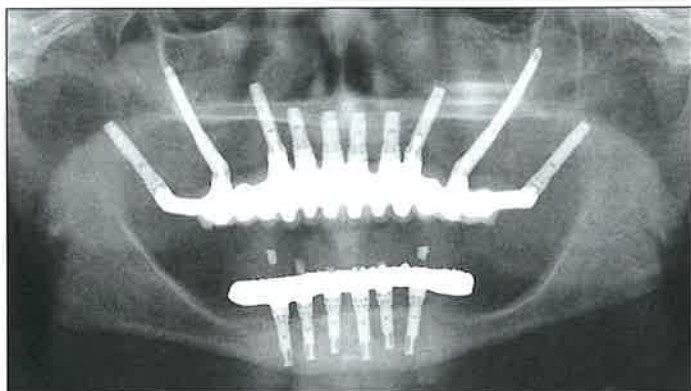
Panoramic radiograph obtained following delivery of definitive porcelain-fused-to-gold prosthesis.
